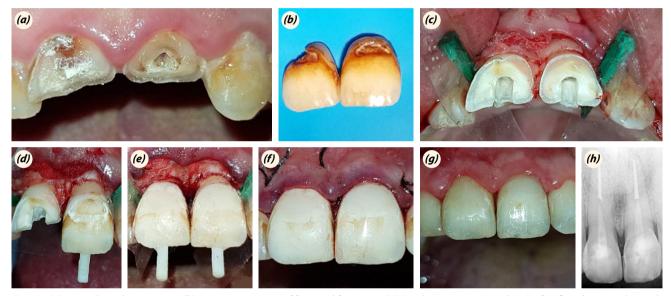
(a) Pre-op buccal appearance. (b) Pre-op appearance of fractured fragments. (c) Canal treatment is completed. After flap elevation, the teeth were isolated from the adjacent teeth. (d) The fragments' compliance were checked. (e) Coronal parts were bonded with dual cure cement. (f) Post-op buccal appearance (g) buccal appearance at three months follow up (h) radiograph at three months follow up.
